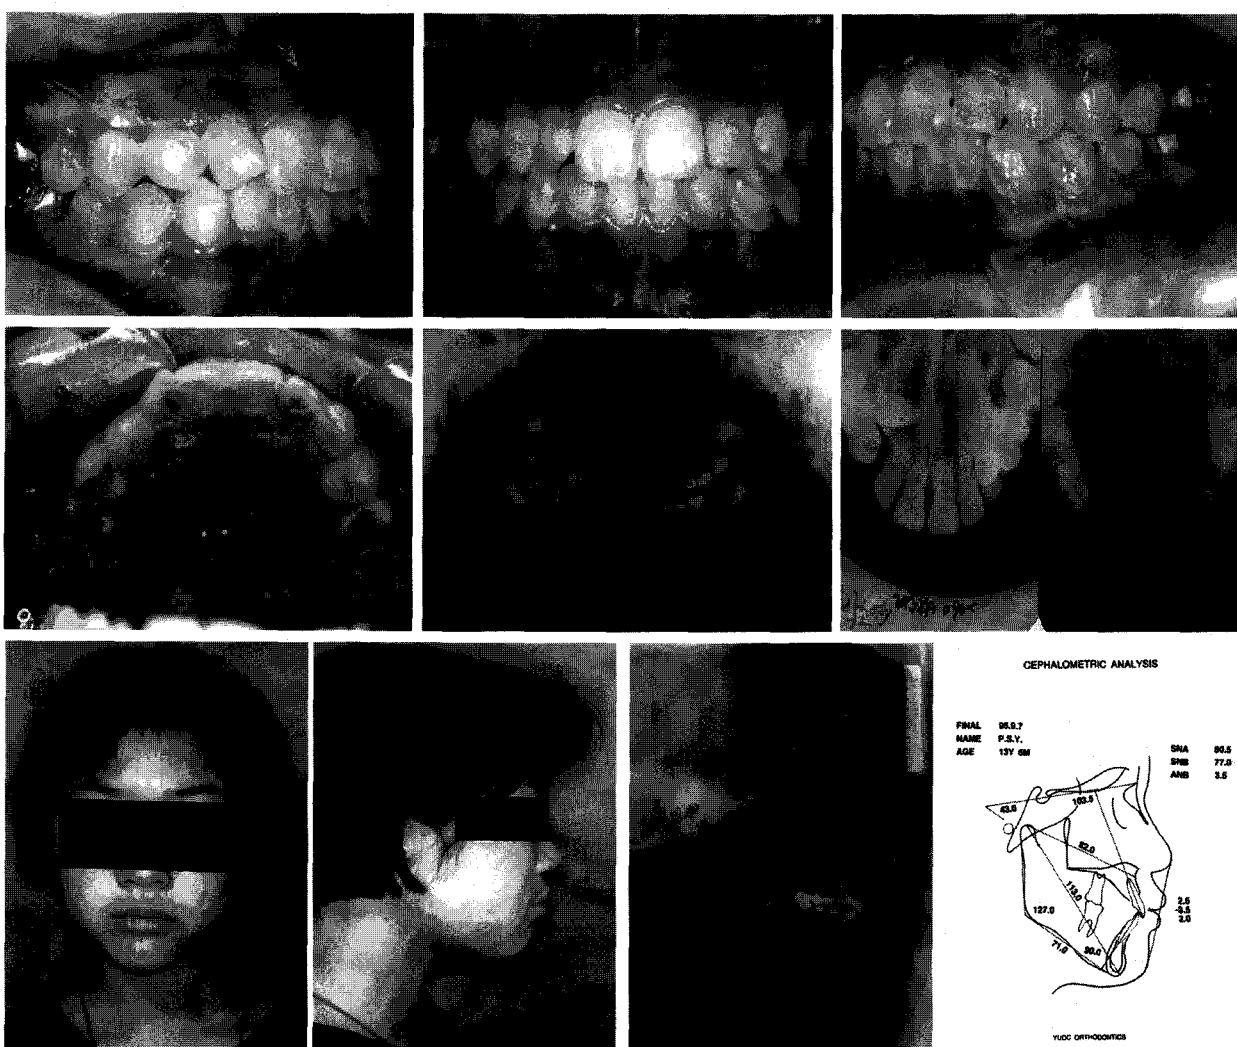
Case 1. Final intraoral photos, facial photos, lateral cephalogram, orthopantomogram, occlusal X-ray, and cephalometric tracing
